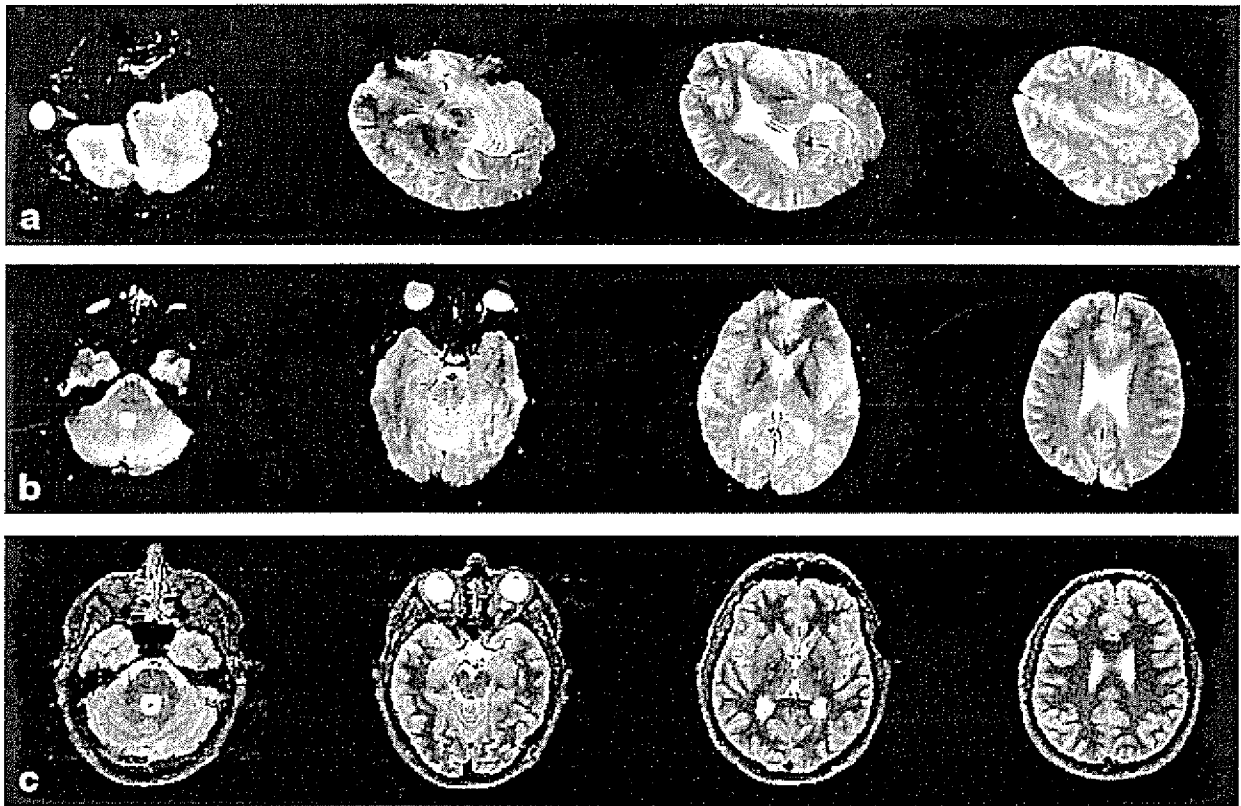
MRI scans from a subject with markedly tilted head position, before (a) and after (b) adjusting the scan geometry. Note that the optimized scan (a) mirrors the slight rotation about the z-axis present in the reference template scan (c).
